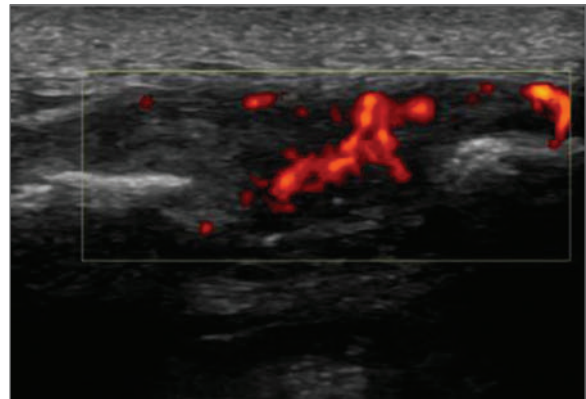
Ultrasound image of the acromioclavicular joint outlined in ► Fig. 2.44. Power Doppler demonstrates that in addition to joint hypertrophy there is a marked synovial vascularity in keeping with synovitis.
